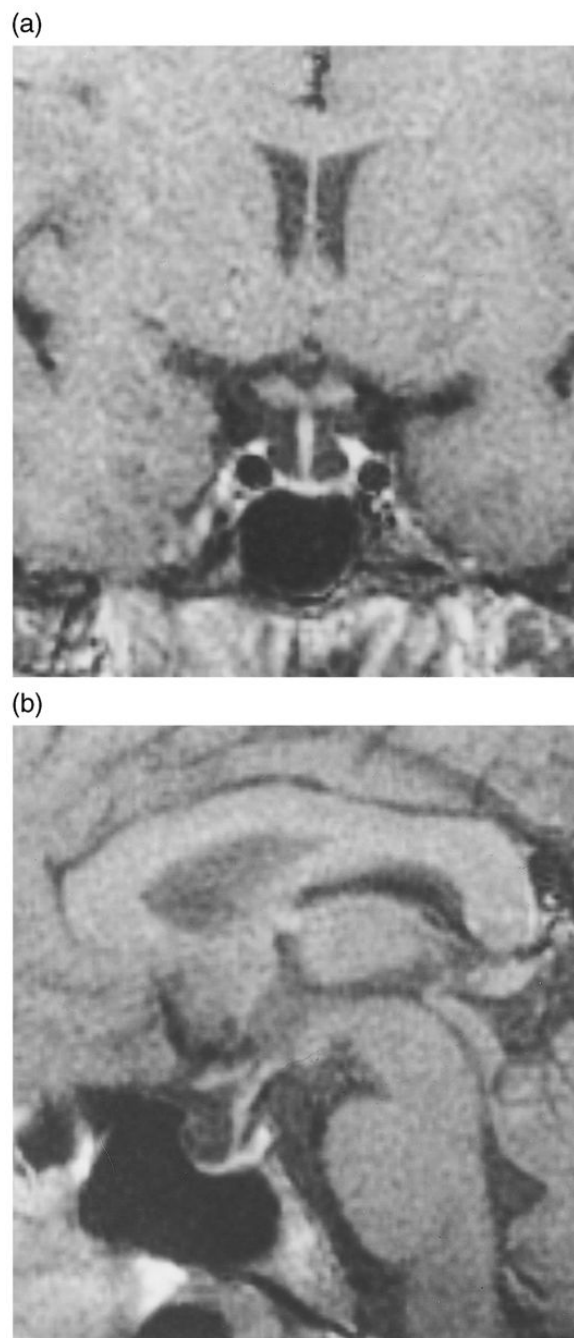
Coronal (a) and sagittal (b) images obtained by magnetic resonance imaging showing the hypoplastic pituitary gland of the patient.
